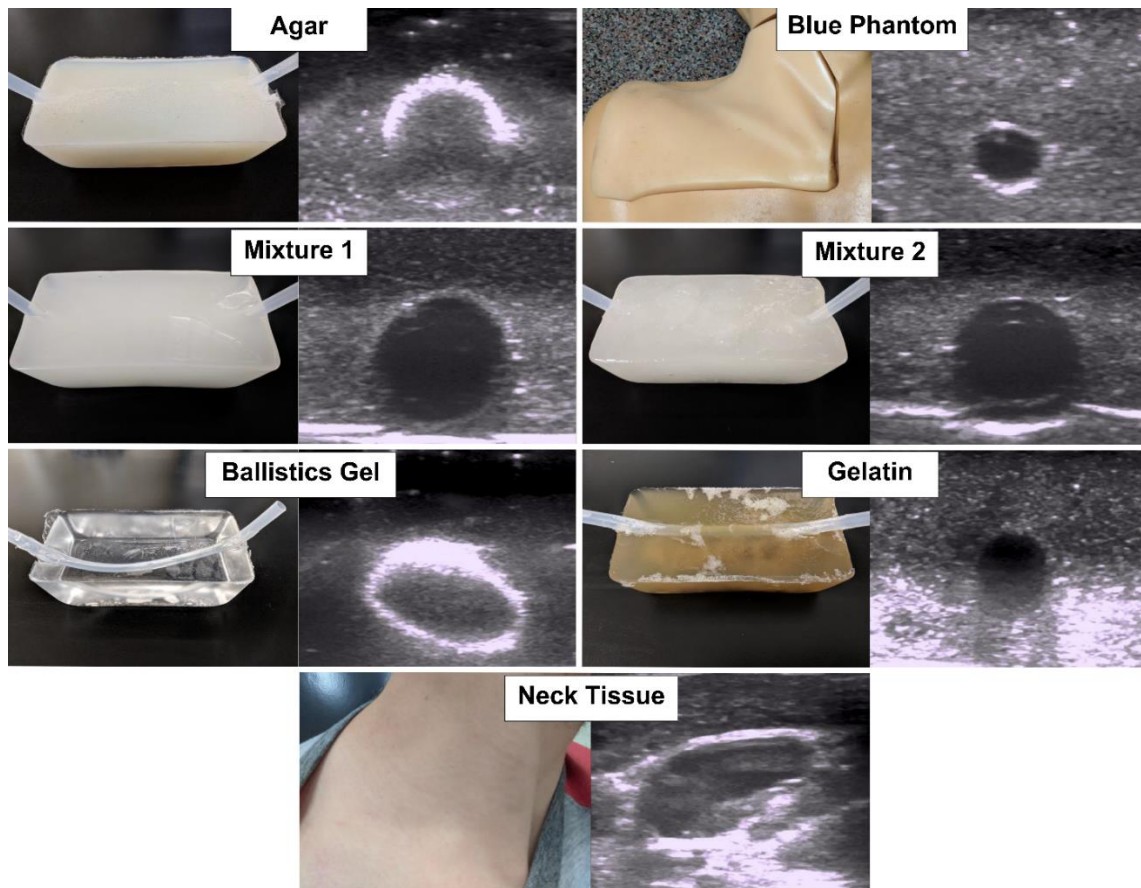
Materials used for ultrasound pairwise comparison testing. One of the two ultrasound images used for each material is shown. The ultrasound machine used was a GE Healthcare Logiq e with a gain set to 70, frequency of 10.0 MHz, and depth ranging from 3.0 cm to 4.5 cm. Focal zone was set to the center of the image. A GE 8L-rs linear vascular transducer was used to scan the material.
